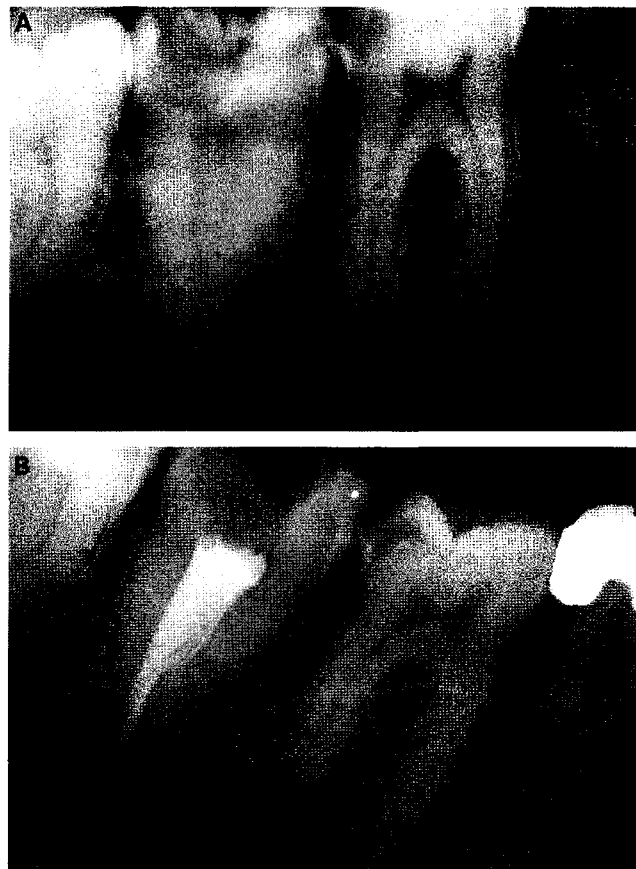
Category I. (A) Preoperative radiograph of the second molar showing fused roots. (B) True C-shaped canal filled with vertical condensation of warm gutta-percha.
